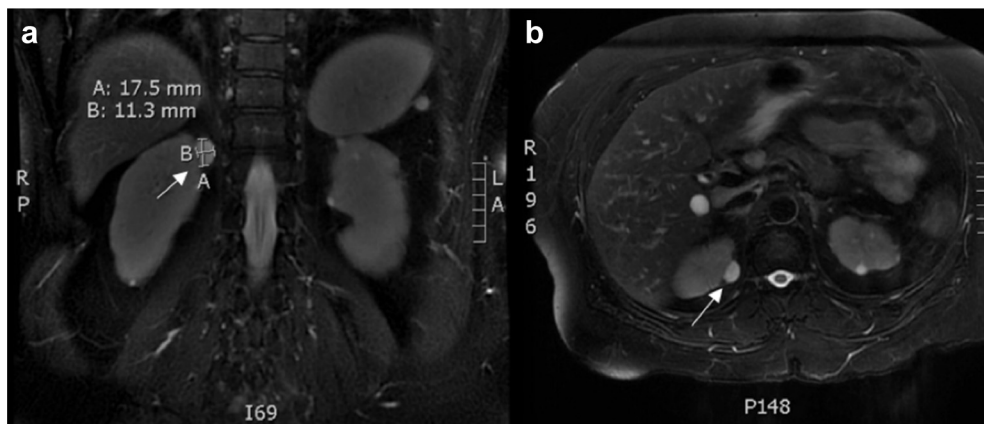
a (left). MRI showing 18 mm × 11 mm mass arising from the superomedial cortex of the right kidney. b (right). Contrast enhanced MRI showing enhancement of the mass.
